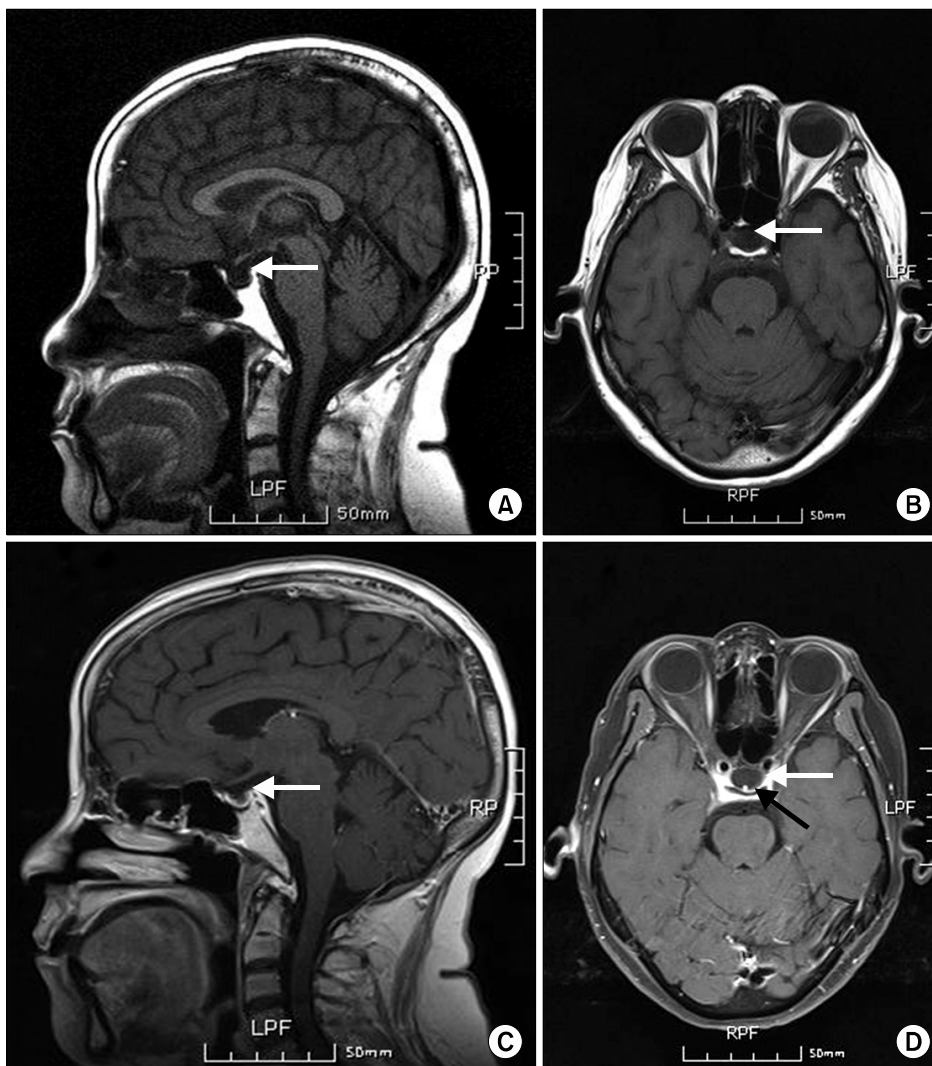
A T1 weighted magnetic resonance imaging revealed low signal changes of the sella turcica on the sagittal (A: without contrast, C: with contrast; white arrows) and transverse sections (B: without contrast, D: with contrast; white arrows) with the pituitary stalk demonstrating a high signal changes (black arrow), which is consistent with the empty sella. No other abnormal signal change of the brain was noted on this study.
